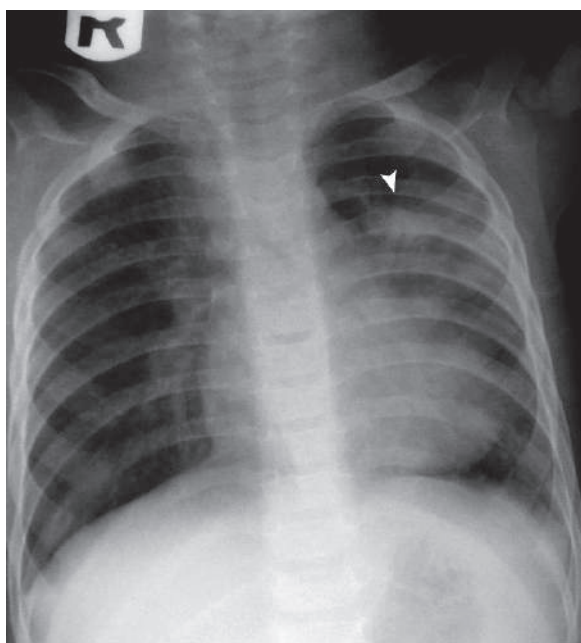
Posteroanterior plain chest radiograph of a 5-year-old child with measles presenting with dyspnea shows ill-defined patchy pneumonia in the upper zone of the left lung (*arrowhead*)
